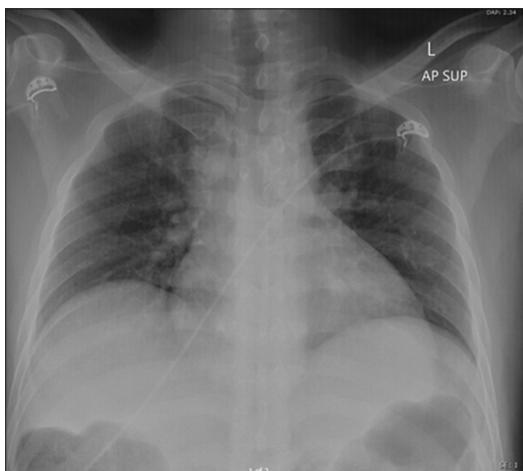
X-ray image on admission. Diagnosis: Normal cardiac configuration, both lung felids show increased bronchovascular markings; however, no detected pulmonary opacities and clear costophrenic angles
